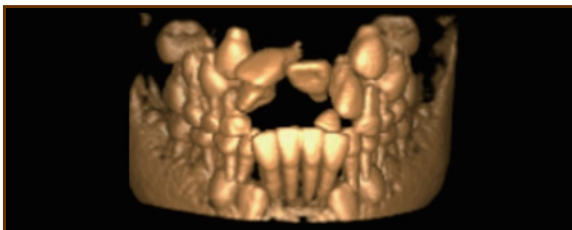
(b): CBCT of the impacted maxillary incisors (Clinical picture from personal collection)
